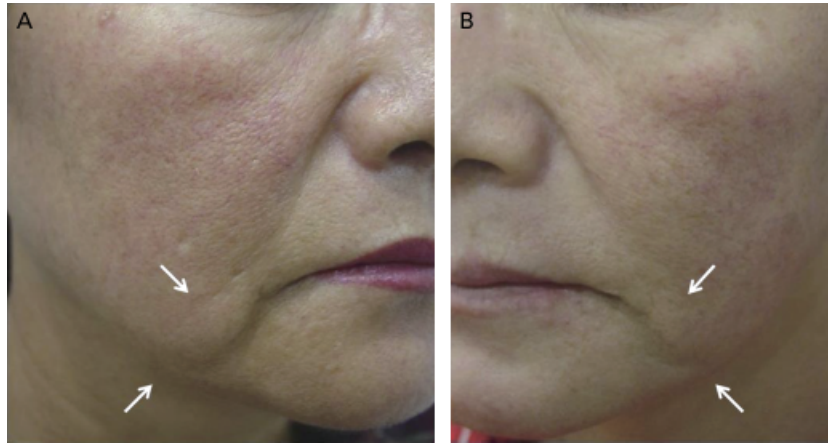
Improvement of jaw line and marionette line after single intense focused ultrasound treatment. (A) Before treatment, (B) 2 months after treatment.
